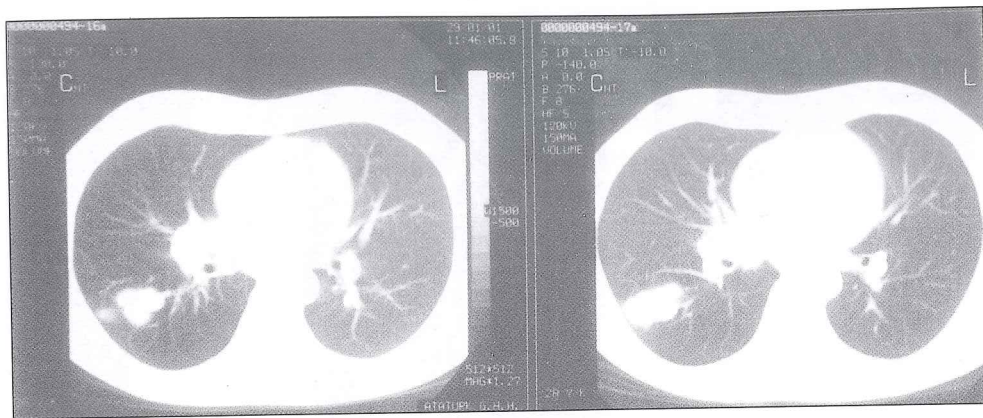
Thorax CT showing a lobulated solid lesion in the right lower lobe.
